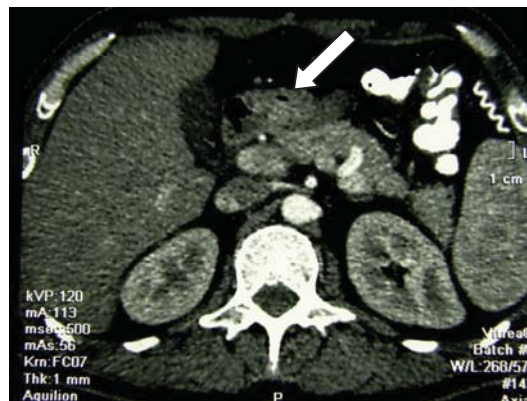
Postoperative multislice computed tomography (MSCT) – lower level of a fibrotic mass without duodenal dilatation
